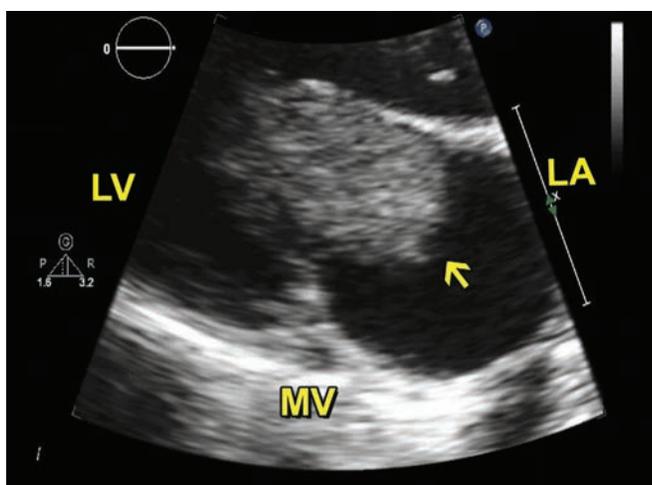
Transthoracic echocardiography. Parasternal long axis view of the mitral valve. (LA: Left atrium; LV: Left ventricle). Arrow points to a large mass within the left atrium and protruding into the left ventricle.
